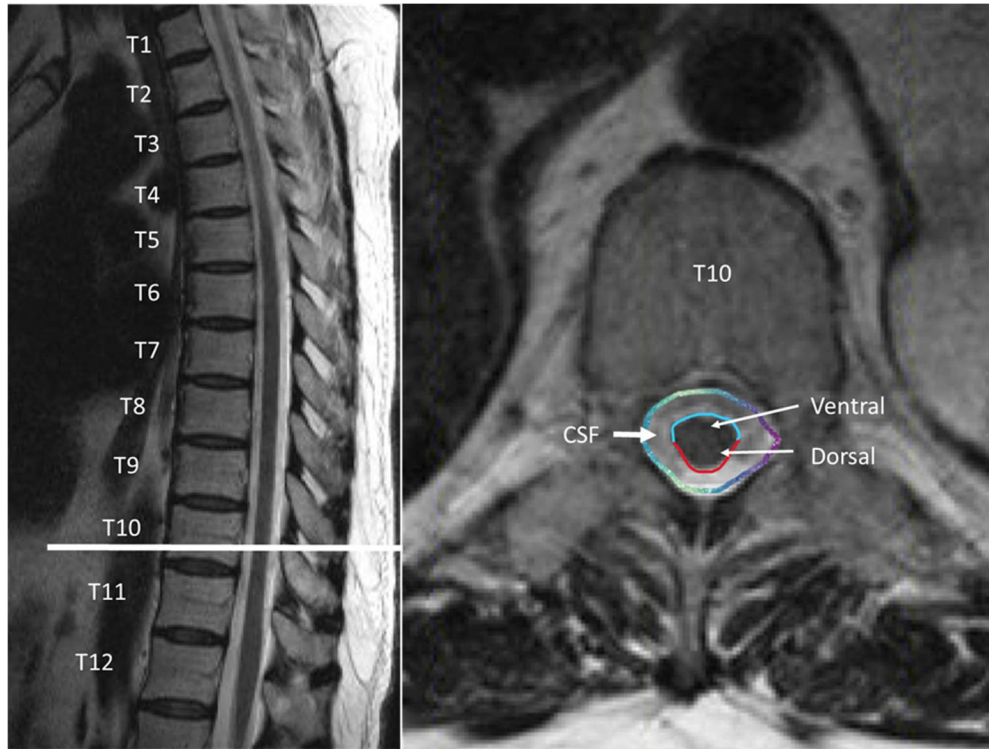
S.6 Sagittal (left) and axial (right) image of the spinal cord in patient P1. All patients underwent a preoperative MRI to ensure that there was no thoracic spinal cord stenosis that would prevent the implantation of the paddle electrode. The axial image mirrors that of the fUSI image. CSF: Cerebrospinal fluid, Ventral: Ventral horn, Dorsal: Dorsal horn.
